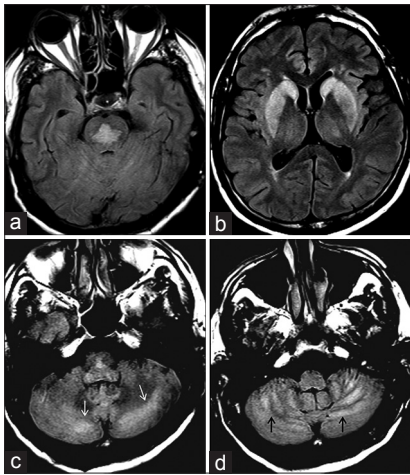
Axial FLAIR MR images of brain showing hyperintensity in (a) central pons, (b) bilateral putamen and caudate nuclei, and (c and d) cerebellar hemispheric white matter
